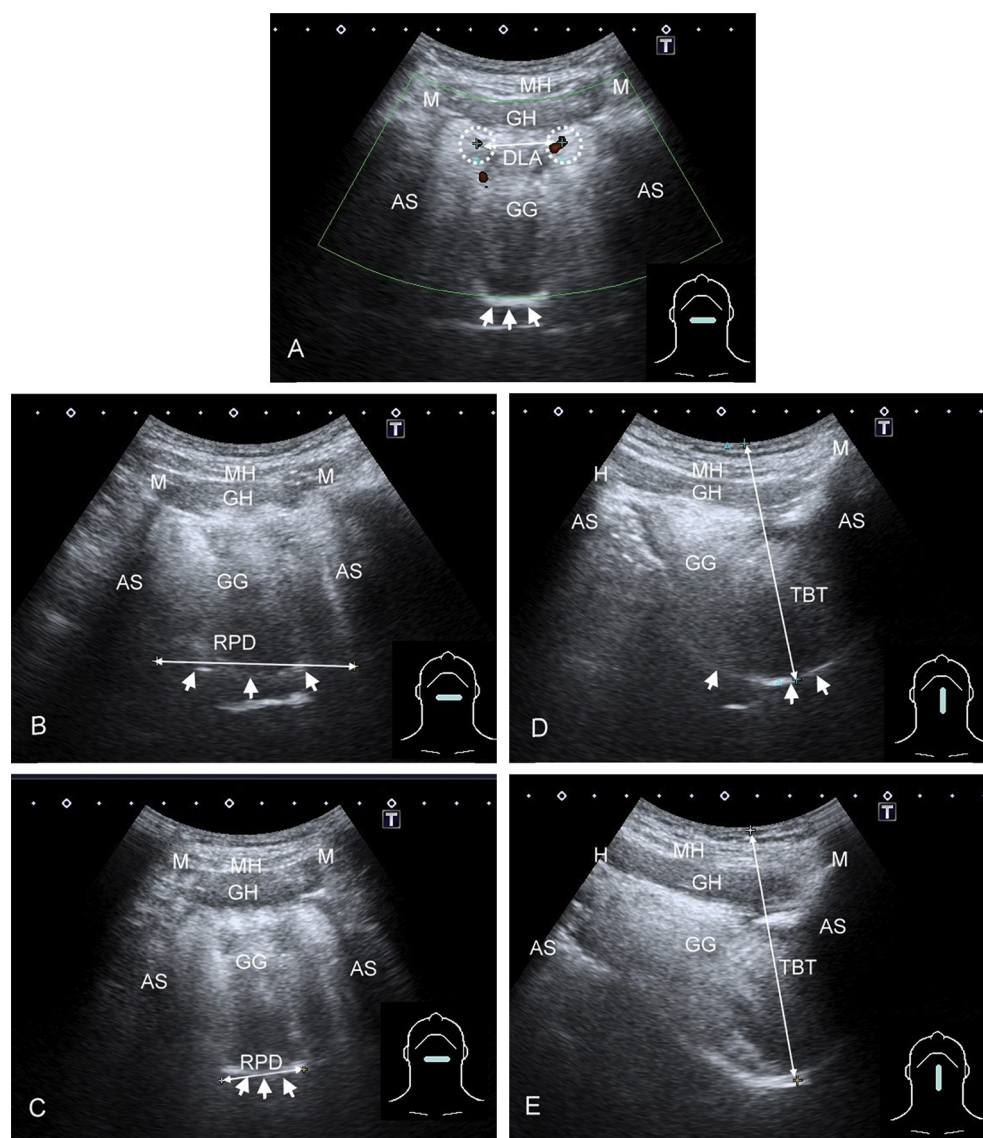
Submental ultrasonograms to delineate various ultrasound parameters in diagnosing severe obstructive sleep apnea syndrome. (A) Lingual arteries (dotted circles) were shown by Power Doppler scan on both sides of lower lateral border of tongue base. Distance between lingual arteries (DLA) was measured; (B) transverse diameter of rectopalatal pharynx (RPD) in resting and (C) under Müller's maneuver; (D) mid-tongue base thickness (TBT) in resting and (E) under Müller's maneuver. Other markings were seen as following: mucosa covering of tongue (whitish arrows), and geniohyoid muscle (GH), mylohyoid muscle (MH), geniohyoid muscle (GG), and acoustic shadow (AS) reflecting the mandible body (M) or hyoid bone (H).
